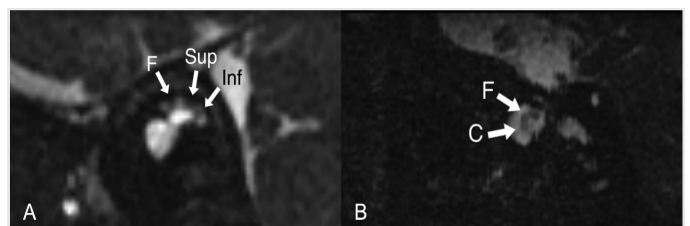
3D CISS T2-weighted MRI images of (A) cochlear aplasia and (B) cochlear hypoplasia
